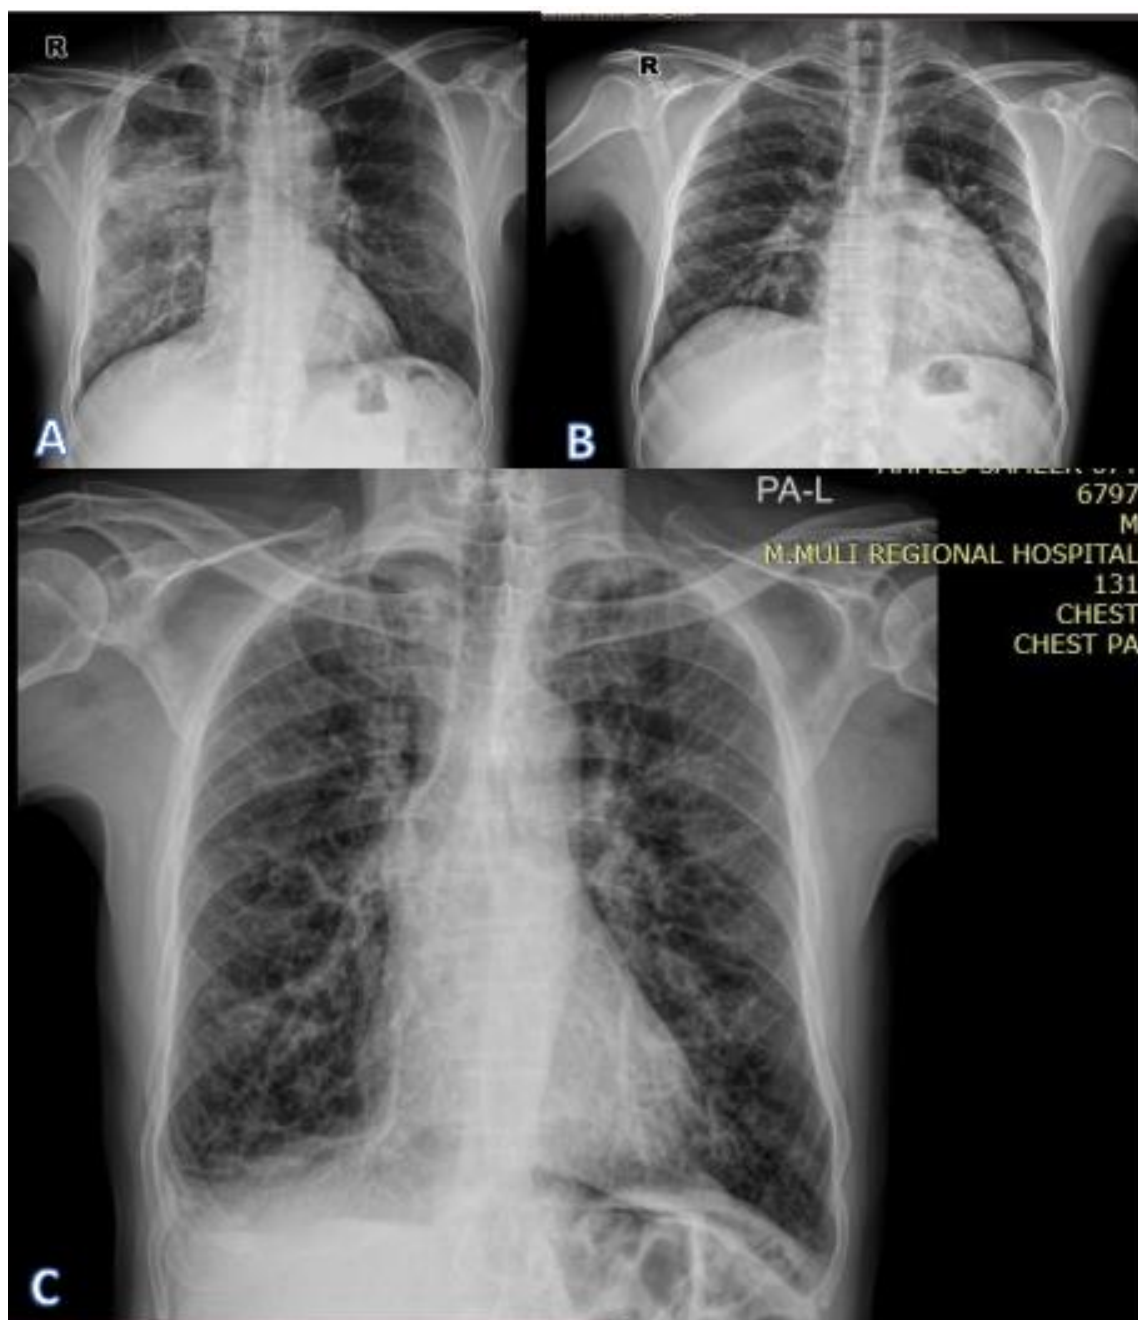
A- CXR – PA view shows Rt middle lung zone mass and distal reticulation; CT further assessment is mandatory. B- CXR- PA view of adult patient suffering significant cardiomegaly, echocardiography is essential for further assessment. No data available if the patient did it in another hospital or not. C- CXR of middle-aged adult male suffering dyspnea, it shows bilateral reticulation in both lung fields (likely to be an interstitial lung disease which is better assessed by CT scan) with obliterated Rt costophrenic recess denoting small amount of pleural effusion which is better assessed by ultrasound.
